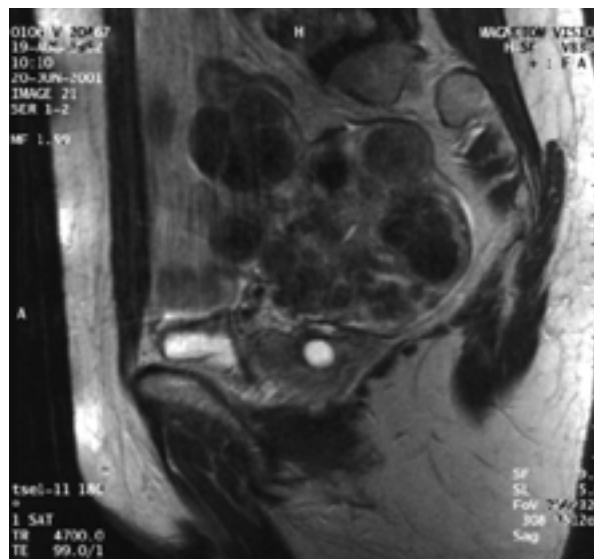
MRI in patient with multiple uterine fibroids responding very well to intrauterine treatment with LNG, with the FibroPlant-LNG IUS in the middle of the picture.
